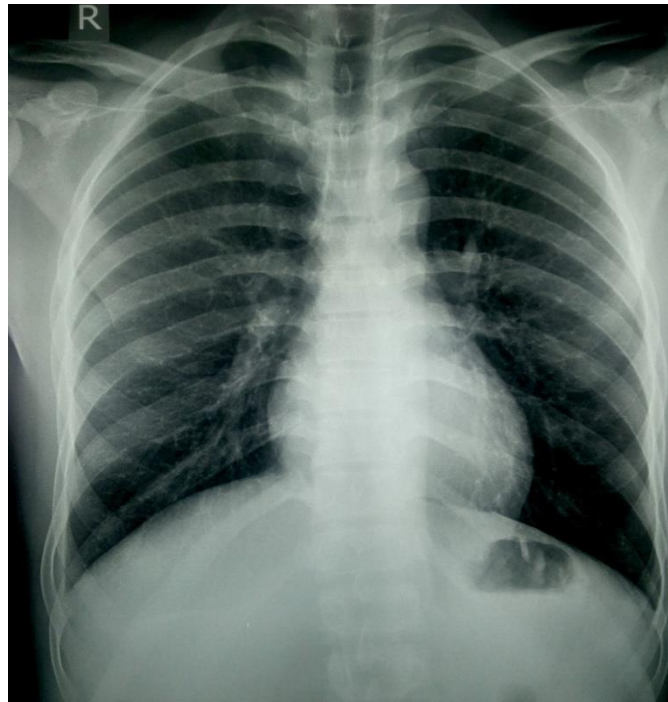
Chest X-Ray PA View showing no free gas under both domes of diaphragm
